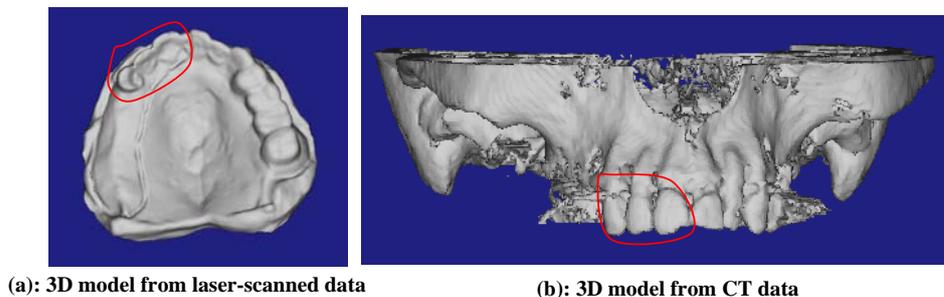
3D reconstructed models respectively from laser-scanned and CT data, the adjacent teeth (labeled in the enclosed red line area) in the edentulous region will be cut for registration
